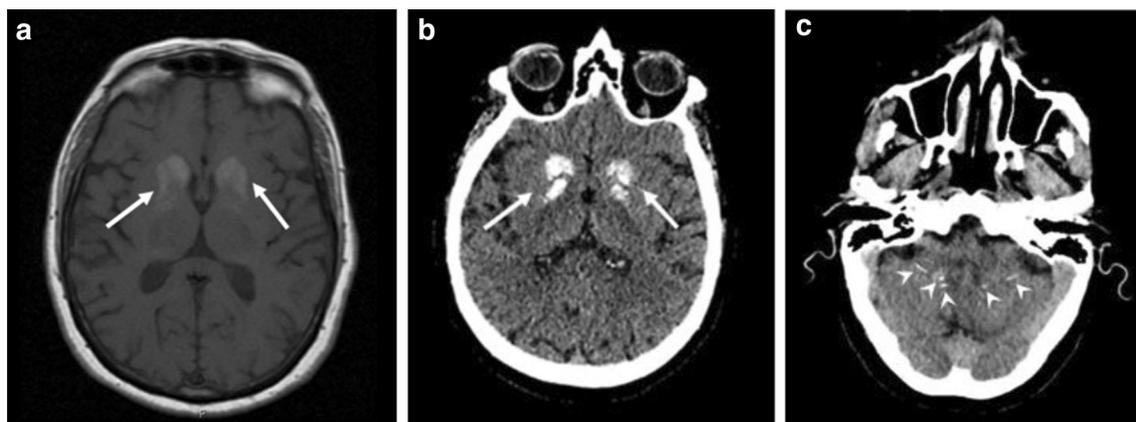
Unenhanced brain magnetic resonance imaging (a) shows homogeneously altered signal intensity in putamen, globus pallidus, and caudate (arrows). Unenhanced computed tomography reveals
